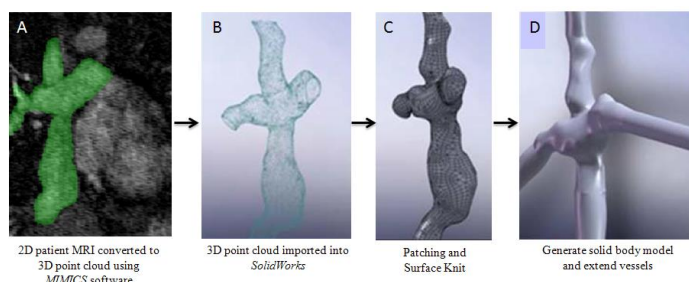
Generation of the Patient-specific Anatomic Model. A. 2D patient MRI converted to 3D point cloud in MIMICS; B. Smooth point cloud mesh imported into SolidWorks; C. Surface knit to solid body; D. Vascular extensions to the solid body TCPC.
